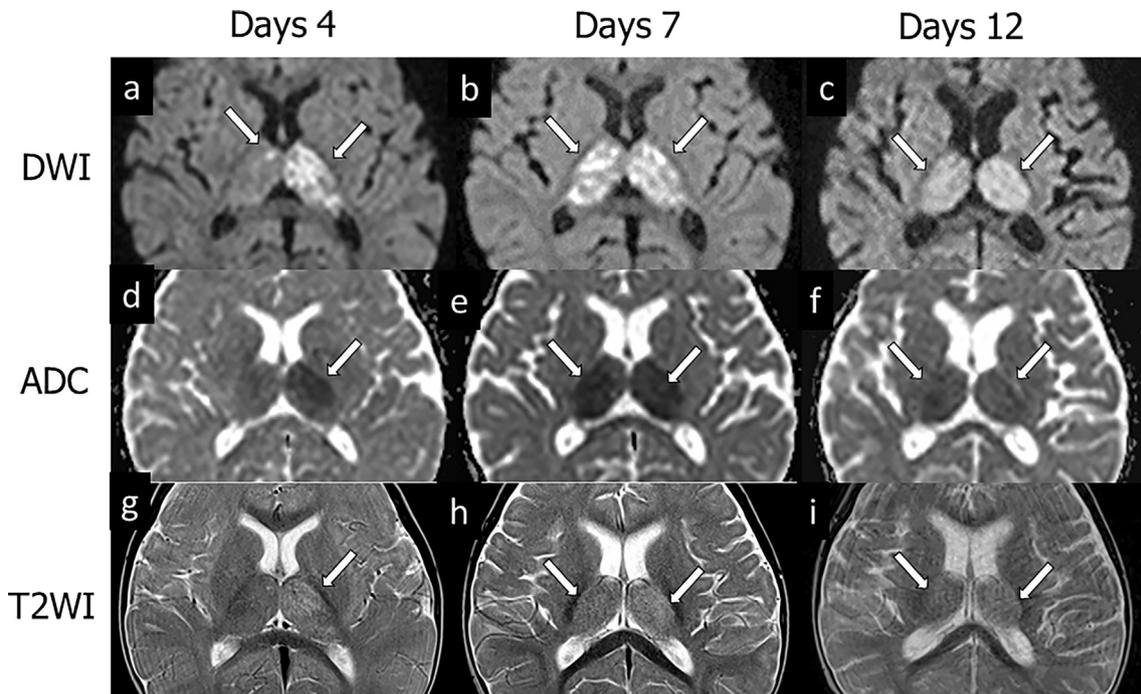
Brain magnetic resonance imaging (MRI) in the acute phase. Brain MRI revealed signal changes in the thalamus, from spotty to uniform, on DWI on days 4 (a), 7 (b), and 12 (c), on ADC on days 4 (d), 7 (e), and 12 (f), and on T2-weighted images on days 4 (g), 7 (h), and 12 (i). Thalamic lesions are indicated by arrows. Abbreviations: MRI: magnetic resonance imaging, DWI: diffusion weighted imaging, ADC: apparent diffusion coefficient.
